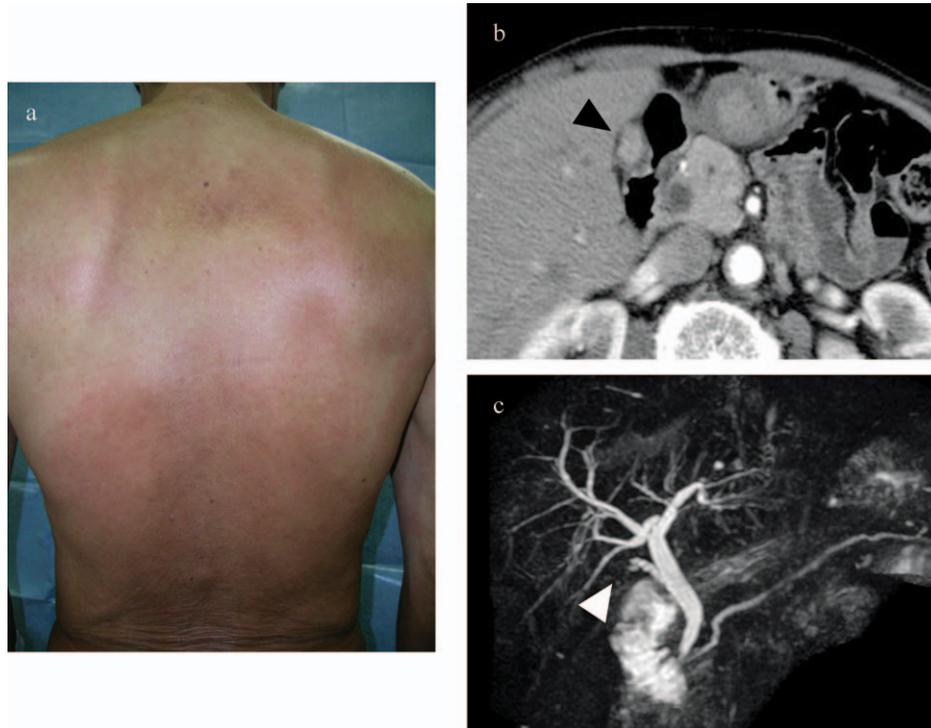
(A) Erythema and scaling involving more than 80% of total body surface. (B) Enhanced CT scan showing hypervascular mass full filling the lumen of the small gallbladder. The air density area beside the gallbladder is the gas within the duodenum. (C) Magnetic resonance pancreatocholangiography revealed absence of pancreaticobiliary maljunction. Note gallbladder lumen is not visualized and other bile ducts are normal.
